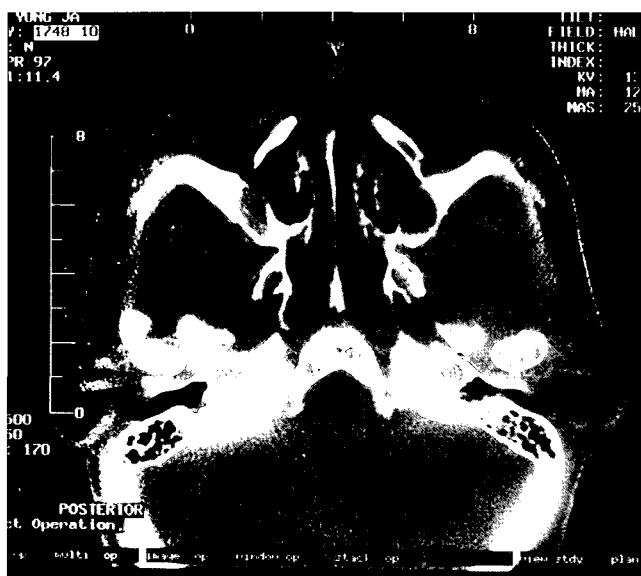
Axial projection of CT scan shows anterior wall depression. The right antrum appears normal and postoperative maxillary cyst is observed on the left antrum.
